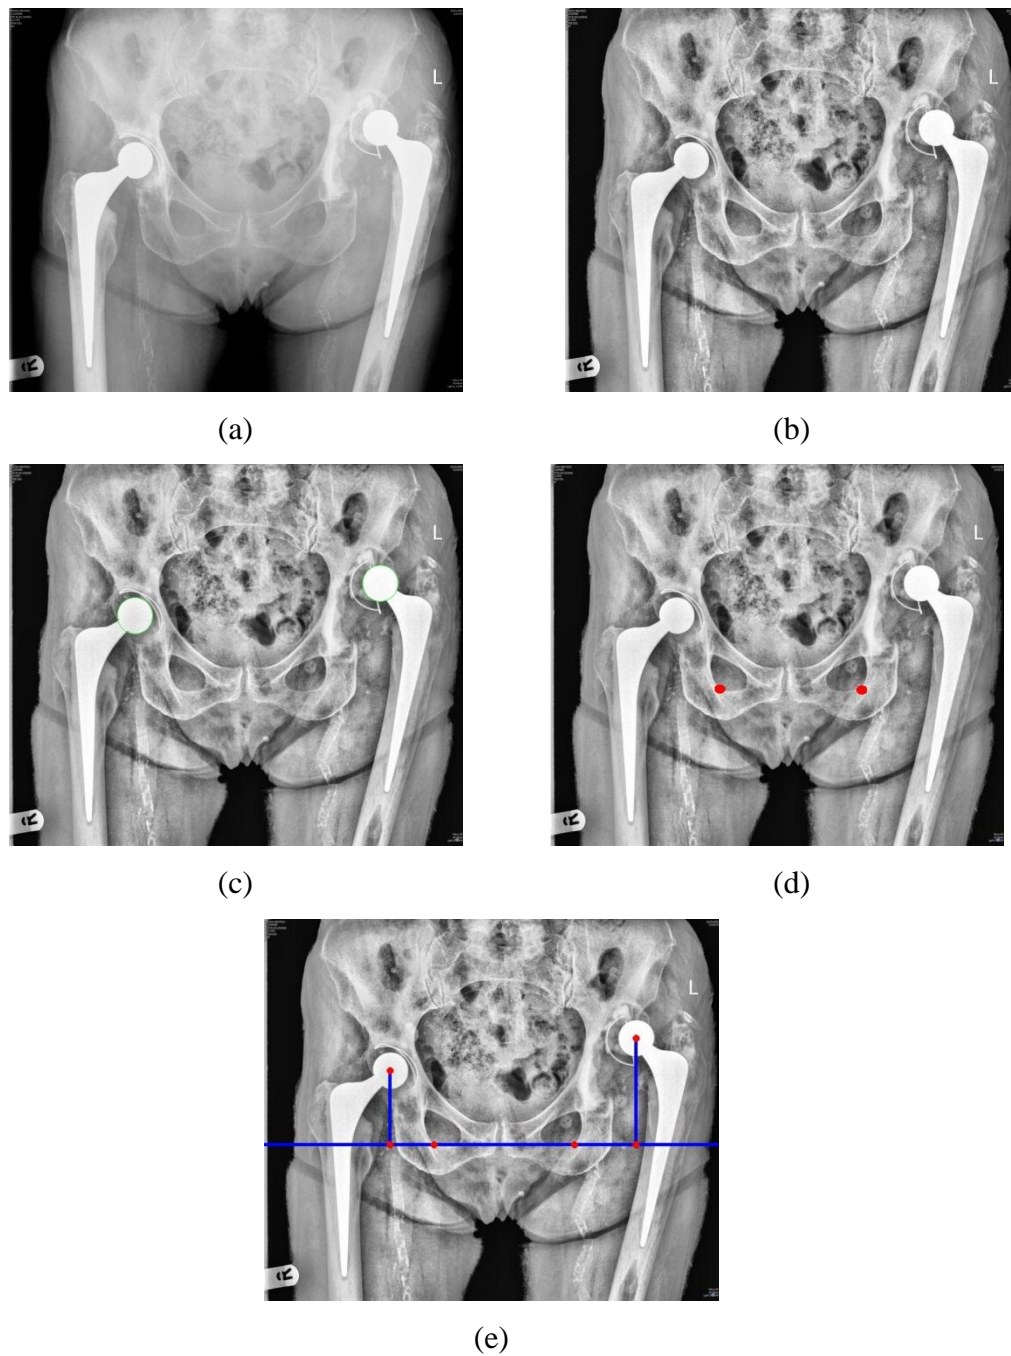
Experimental Results (a) original X-ray images (b) Enhanced Image (c) Hough transform result to determine the two centre points of prosthesis head (d) Filtered Back Projection to determine the key points of the tearbone (e) The final result.
